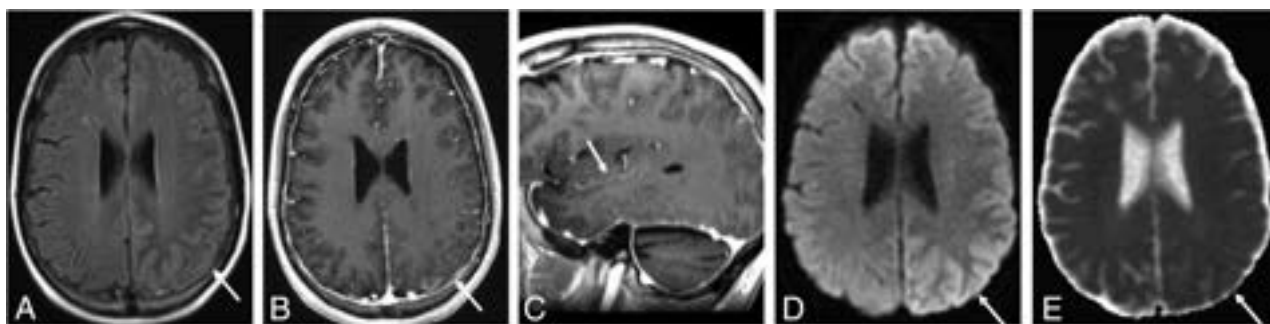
A 37-year-old man diagnosed with PIPG. He had a history of pineoblastoma treated with resection and a posterior fossa meningioma treated by resection and whole-brain irradiation 12 years before, and he presented with migraine-like headache, seizure, right-sided hemiparesis, and aphasia. He was treated with verapamil, aspirin, and valproic acid. He completely recovered from the symptoms. A FLAIR image (A) shows hyperintensity (arrow) with leptomenigeal enhancement in the left temporoparietal region on the axial (B) and sagittal (C) postcontrast T1-weighted images (arrows). Diffusion-weighted imaging (D) and ADC (E) show vasogenic edema (high signal on DWI without low signal on ADC) (arrows).
